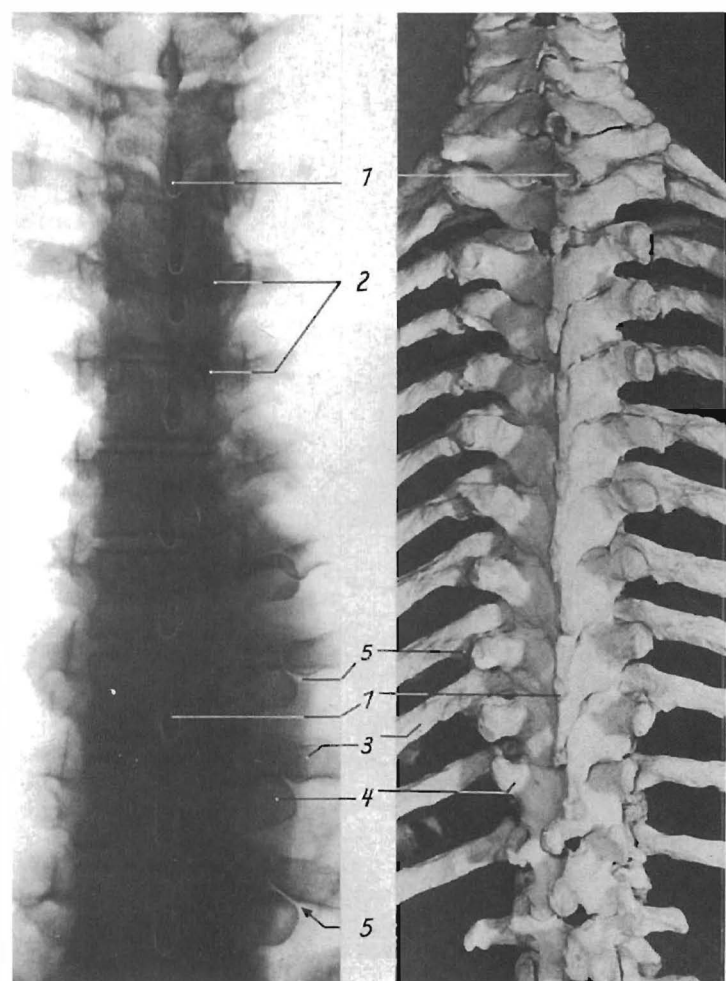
Comparison of the anatomical structures in the dorsal view of the thoracic spine (skeleton) with the anteroposterior X-ray. 1, Spinous process; 2, pedicles; 3, ribs; 4, transverse process; 5, transversocostal joint
